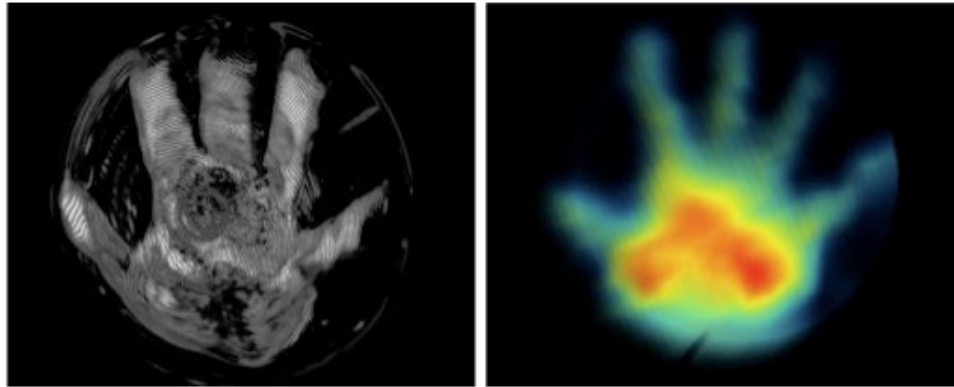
3D reconstructions using the old test software; Ultrasound (left) and EIM (right).
